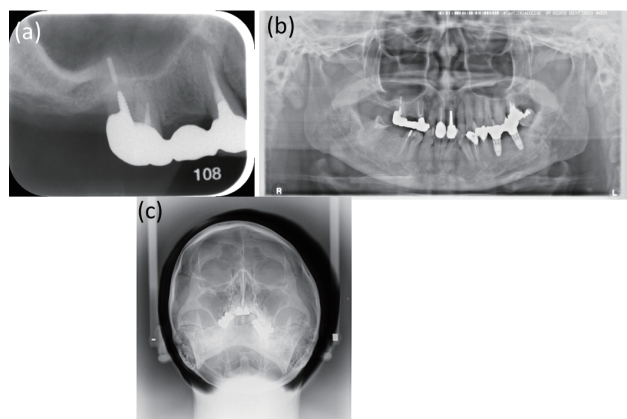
(a) Periapical, (b) panoramic, and (c) Waters radiographs showing no abnormal findings in the dentition or maxillary sinuses.
